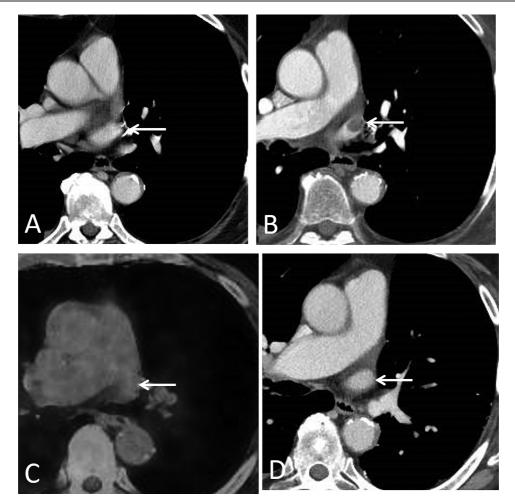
A, Axial contrast-enhanced CT image (mediastinal window), obtained 5 years after the left upper lobectomy, shows a patent left superior pulmonary vein stump (arrow). B, Axial contrast-enhanced CT image (mediastinal window), obtained 7 years after the left upper lobectomy, shows a filling defect within the left superior pulmonary vein stump (arrow). C, Axial fused PET/CT image (obtained 3 days after B) demonstrates lack of FDG uptake at the level of the left superior pulmonary vein stump (arrow), suggesting a non-tumor thrombus. D, Axial contrast-enhanced CT image (mediastinal window), obtained 3 months after B, shows resolution of the left superior pulmonary vein stump thrombus (arrow).
